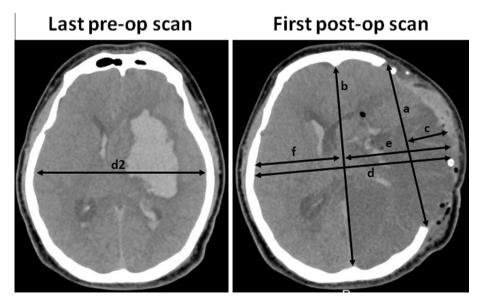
Brain morphometric measurements using Flint's method on pre-operative (left) and post-operative (right) axial CT scans. Line a = maximum hemicraniectomy diameter. Line b = maximum anteroposterior diameter. Line b = midline. Line c = extracerebral herniation (extracerebral herniation index = Line c/Line a). Line d = maximum diameter taken at CT scan slice depicting the greatest brain excursion. Line e and Line f = distances from either surface of the brain to the midline. Line d2 = maximum diameter seen on pre-operative CT scan, taken at approximately the same level taken to measure Line d (Line d – Line d2 = lateral brain expansion).
